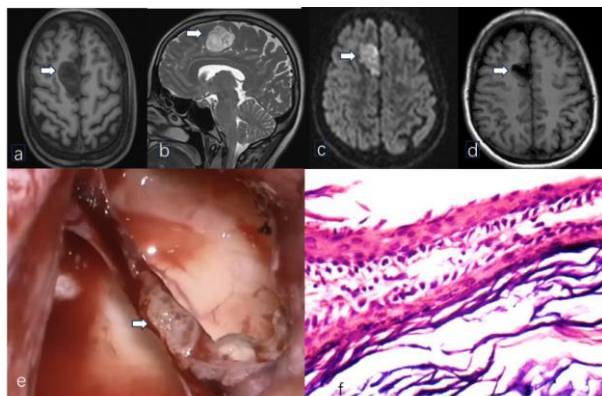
a. Axial T1-weighted MRI showing hypointensity. b. Sagittal T2-weighted MRI showing hyperintensity c. Diffusion-weighted imaging (DWI) demonstrating marked hyperintensity, consistent with an epidermoid cyst. d. Axial postoperative MRI
